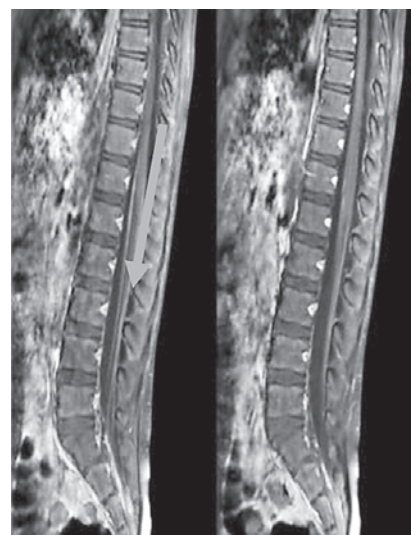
Radiographic features of GBS contrast T1 MRI lumbosacral. Typical findings in GBS - nerve root thickening and enhancement surrounding the conus and the cauda equina
